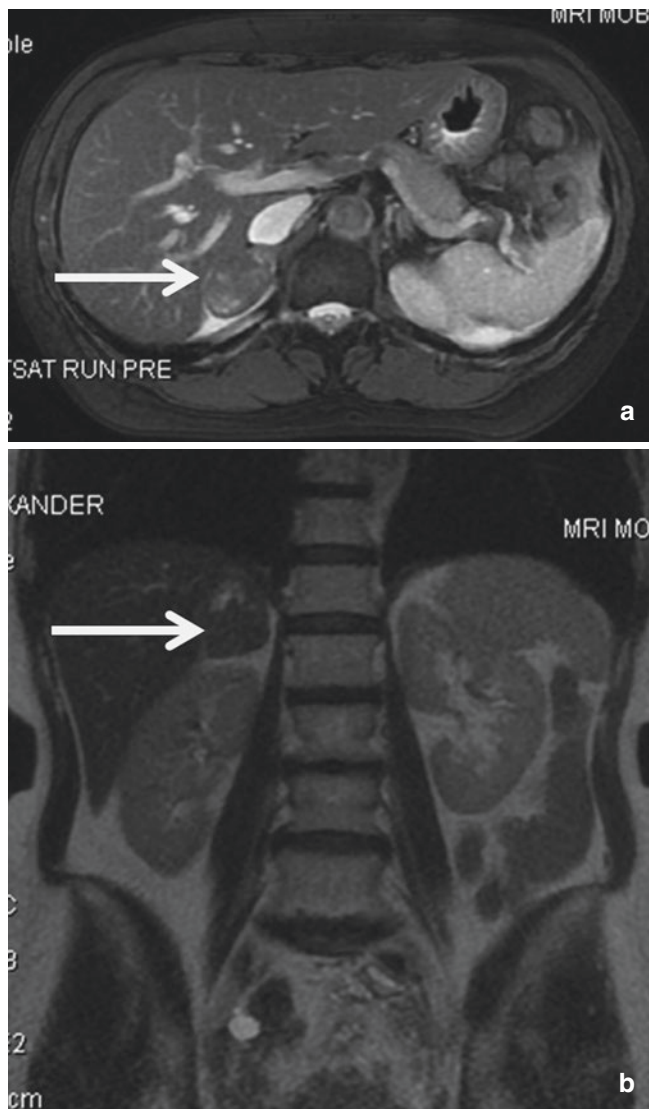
Magnetic resonance imaging (MRI) scan, right adrenal tumor (a - transverse view, b - anterior view). There is a right adrenal lesion measuring 3.4×1.9 cm (arrow). It demonstrates significant loss of signal intensity on out-of-phase imaging. This is heterogeneously hyperintense on the T2-weighted images. It demonstrates low-signal intensity on the fat-suppressed gradient echo sequence and demonstrates heterogeneous enhancement following the administration of contrast
